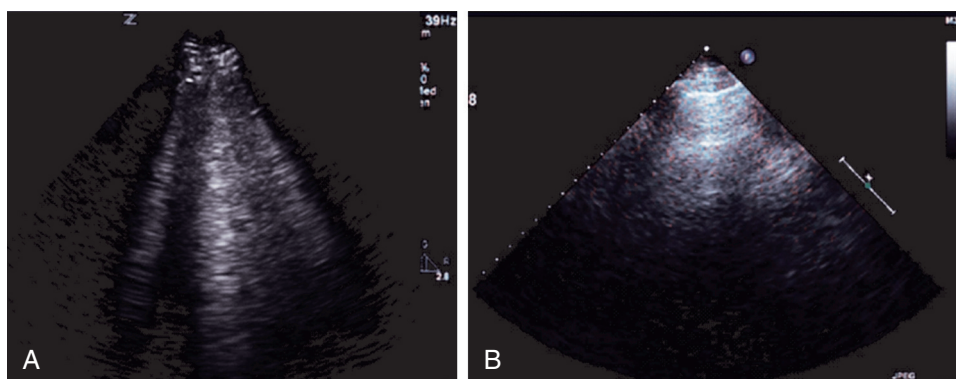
FIGURE e14-9 Sonographic B lines from lung ultrasound. Left, Multiple sonographic B lines or “ultrasound lung comets.” Right, Normal lung on ultrasound examination.
